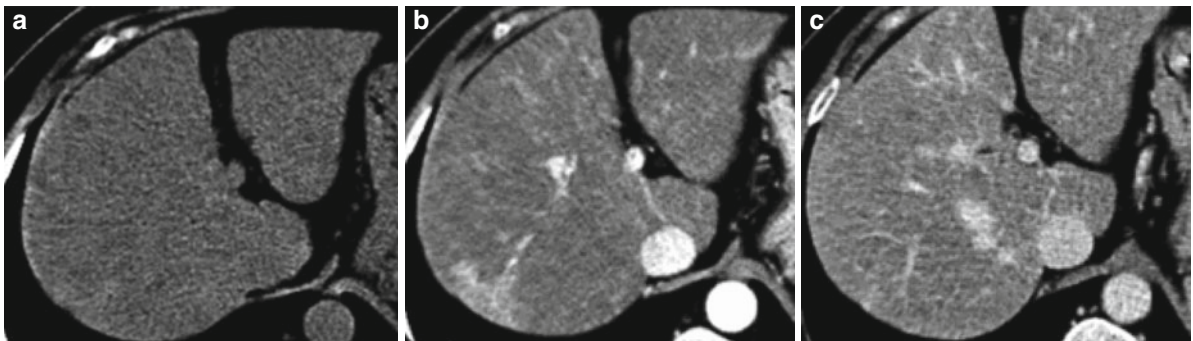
CT scans show transient hepatic attenuation difference (THAD) in a cirrhotic liver. (a) Transverse nonenhanced CT image demonstrates no obvious liver lesion. (b) Corresponding image obtained during the hepatic arterial phase shows a peripheral wedge-shaped homogeneously
